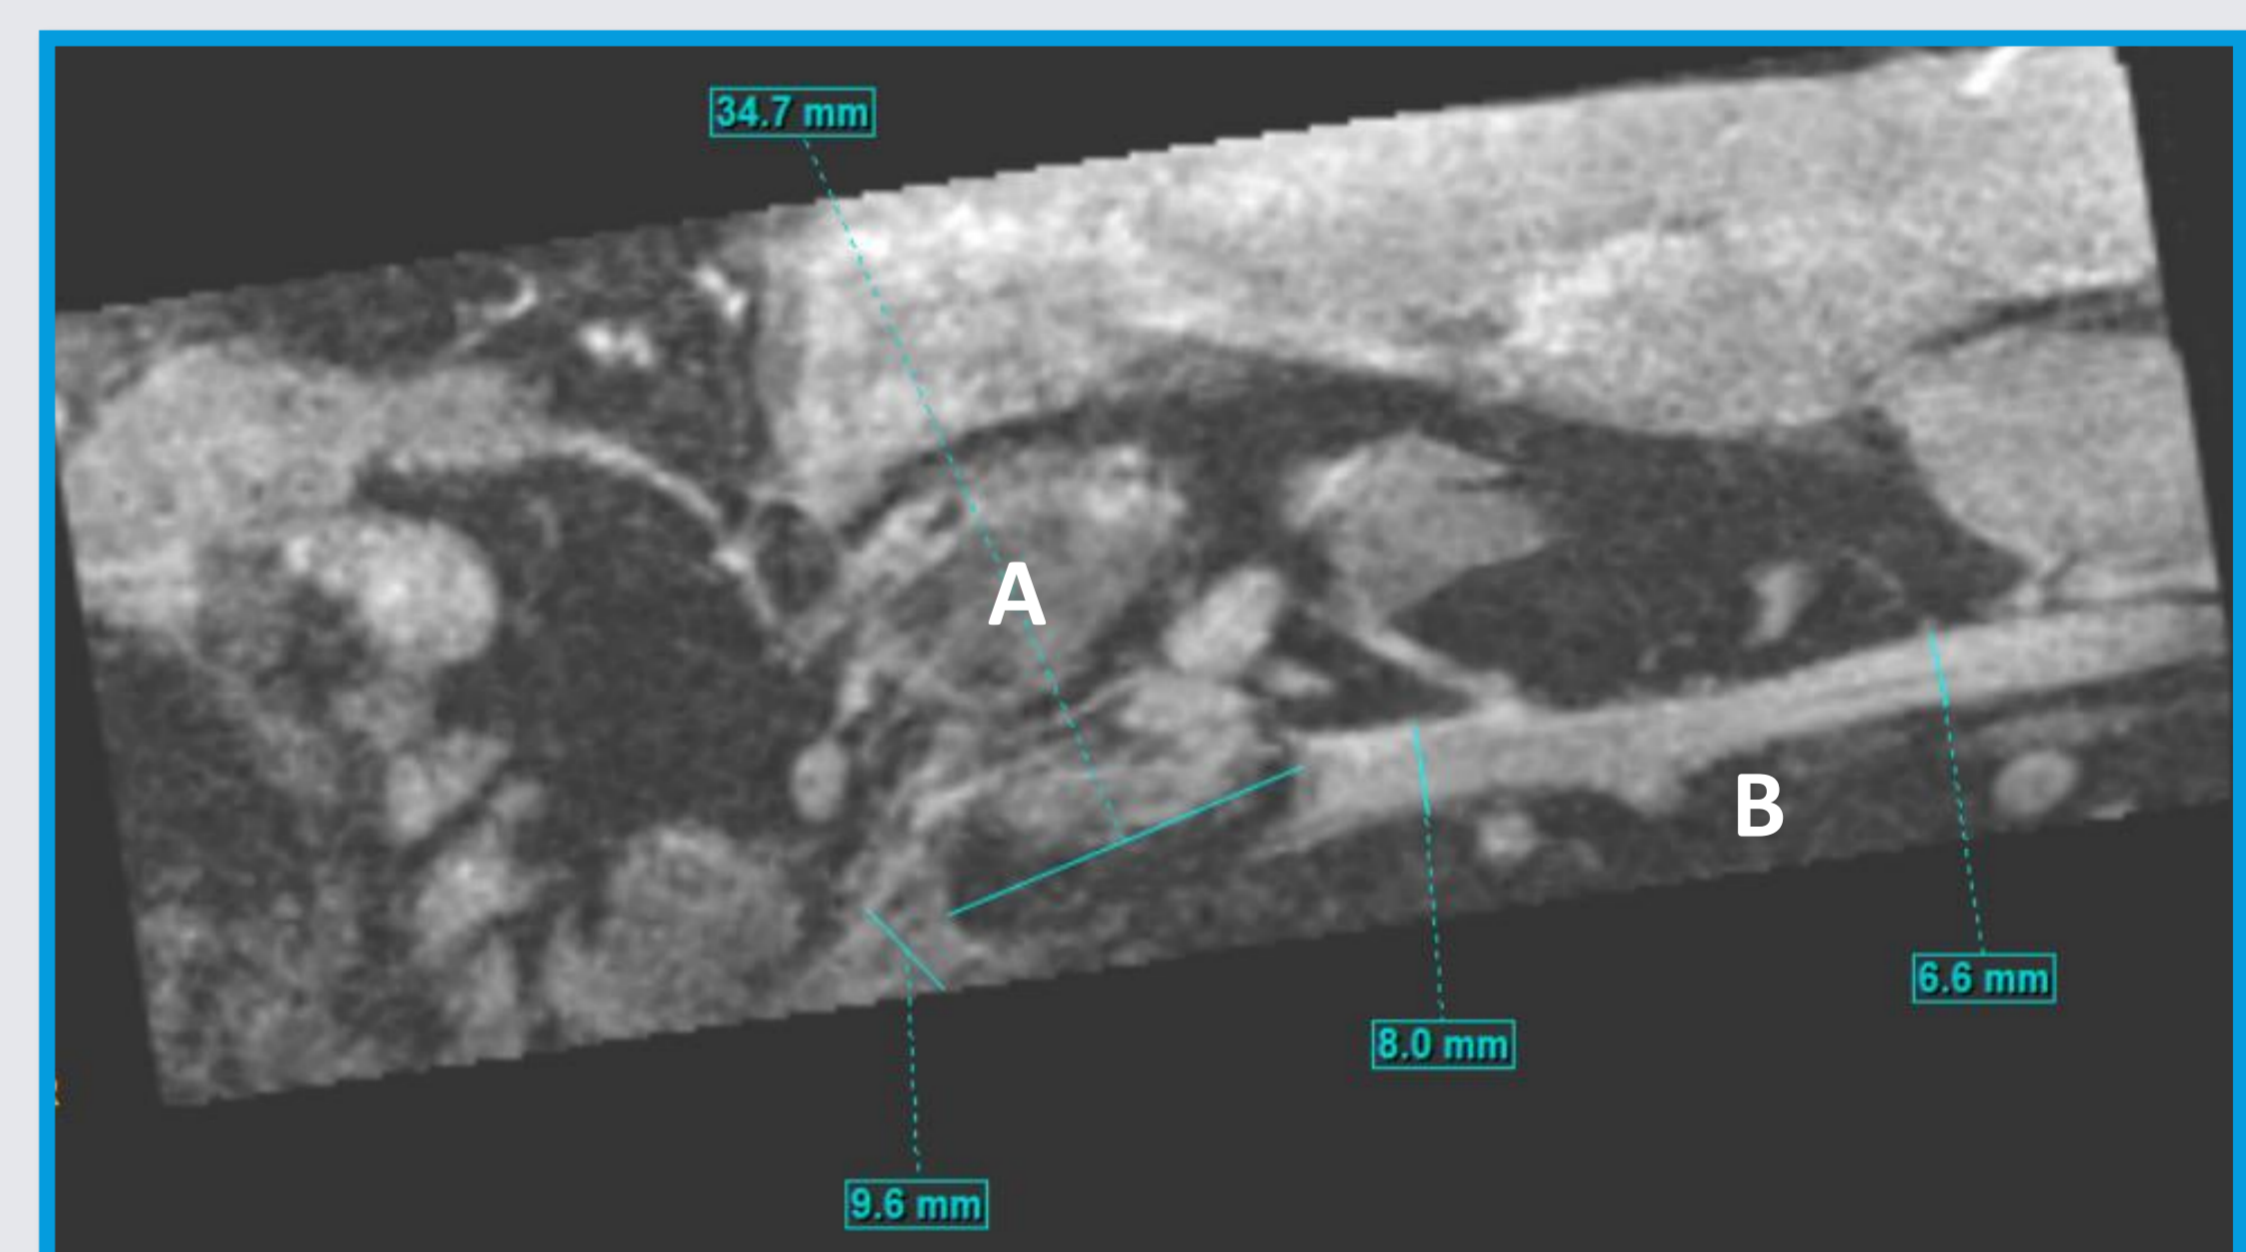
Corresponding MRI with fibrous callus (A); subclavian artery (B)
